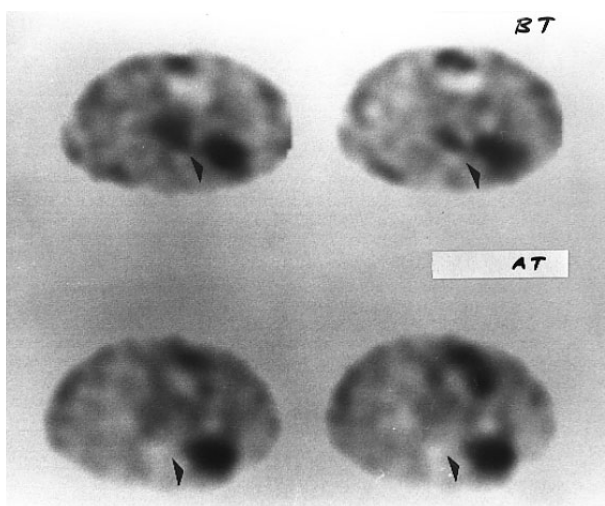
Transverse ^{201}Tl SPECT images of R(-) and p53(-) patient 15 with a tumor (▶) in the left middle lung area: BT (upper row) and AT (below row) images.
